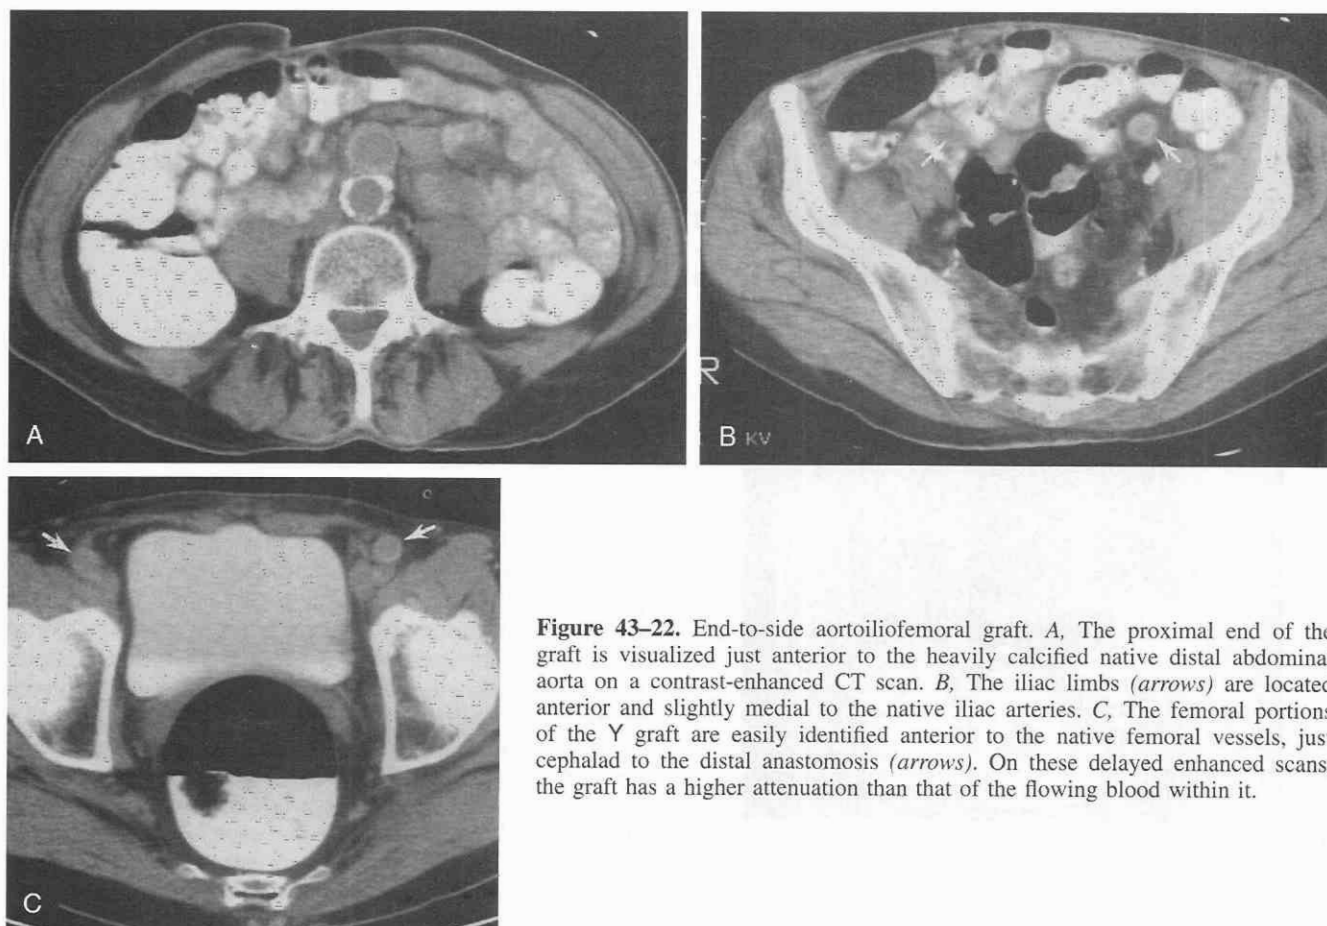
End-to-side aortoiliac bifurcation graft. *A*, The proximal end of the graft is visualized just anterior to the heavily calcified native distal abdominal aorta on a contrast-enhanced CT scan. *B*, The iliac limbs (arrows) are located anterior and slightly medial to the native iliac arteries. *C*, The femoral portions of the Y graft are easily identified anterior to the native femoral vessels, just cephalad to the distal anastomosis (arrows). On these delayed enhanced scans, the graft has a higher attenuation than that of the flowing blood within it.
